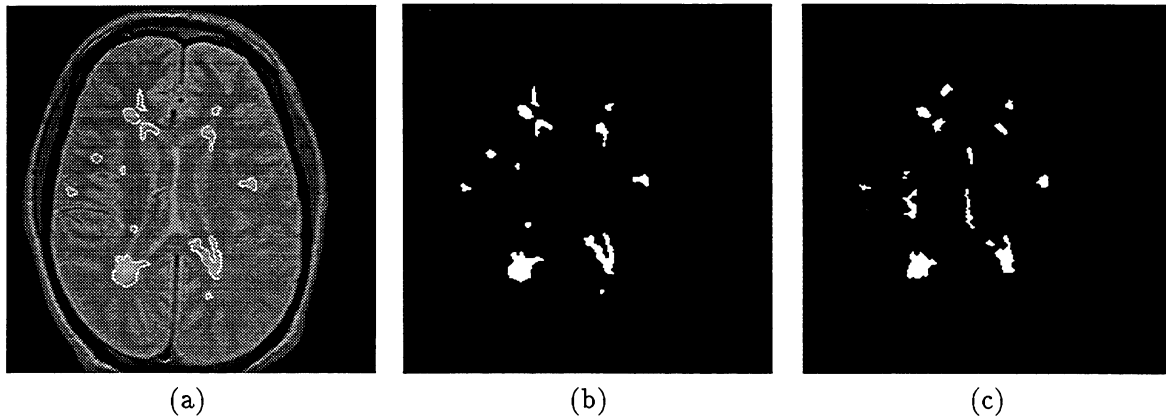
Lesion segmentations of an MR image slice. (a) The PD-weighted image overlaid with manually drawn lesion outlines. (b) The manual lesion segmentation as a binary mask. (c) The semi-automatic lesion segmentation. The similarity index calculated between (b) and (c) is 0.63.
